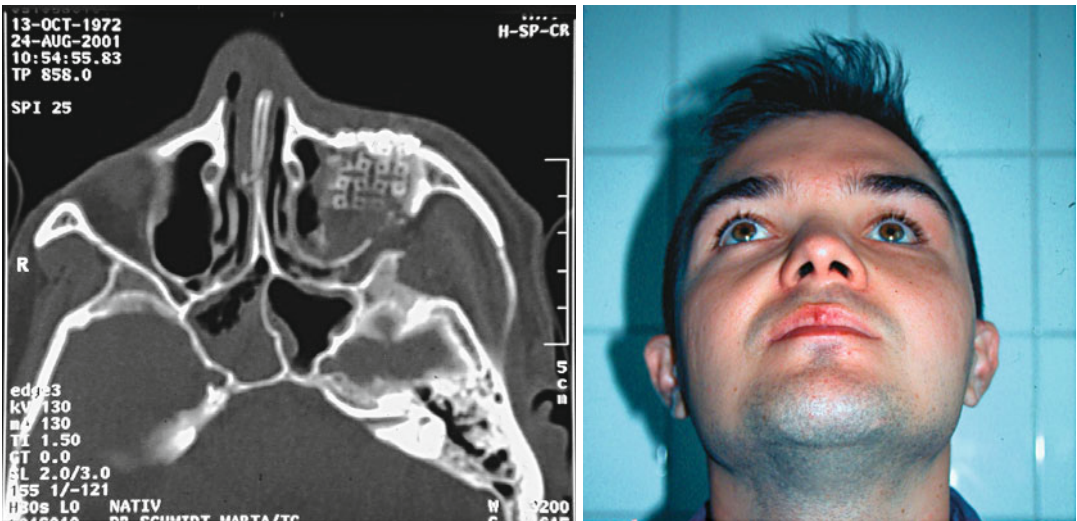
Axial CT image with the implants in place. Postoperative photography: symmetric face, no diplopia
